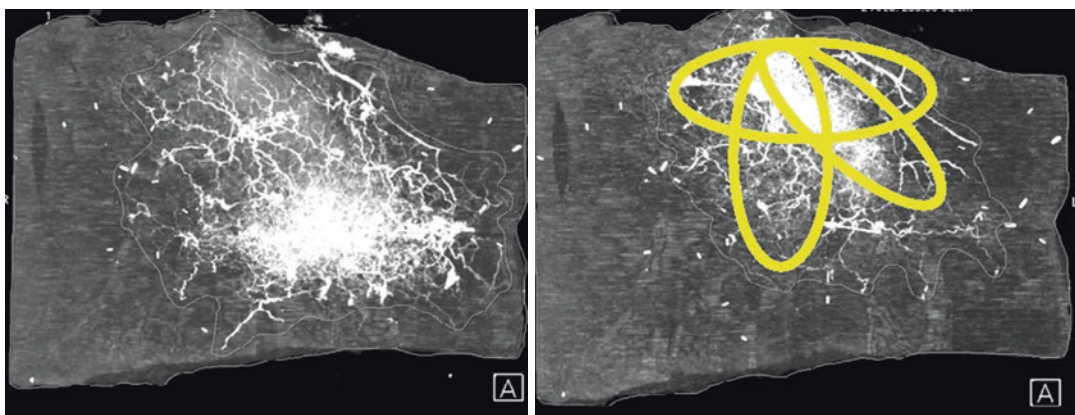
Anatomical study using 3D-rendered computed tomographic angiography to demonstrate the vascular territory of the profunda artery perforasome in a human
